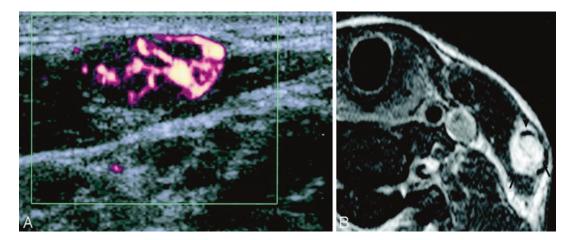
Sonographic and MR images obtained in a vascular malformation of the left external jugular vein
